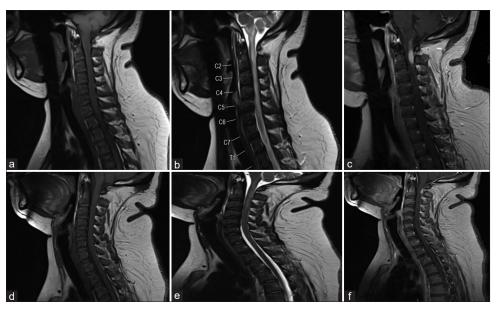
Magnetic resonance imaging of the cervical spine demonstrating T1 hypointensity (a), a long-segment T2 hyperintensity (b) patchy intramedullary enhancement (c) but no significant cord enlargement (a-c). Posttreatment magnetic resonance imaging performed a week later demonstrating significant improvement in imaging findings (d, T1-weighted; e, T2-weighted; and f, postcontrast)
